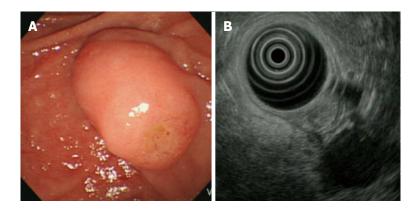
A duodenoscopic image showed an enlarged major papilla with central umbilication and fine nodularity on ampullary orifice (A), endoscopic ultrasonography at the major ampulla revealed a 1.1 × 0.9-cm, slightly hypoechoic round ampullary mass confined to the submucosa without definite wall disruption or adjacent invasion (B).
